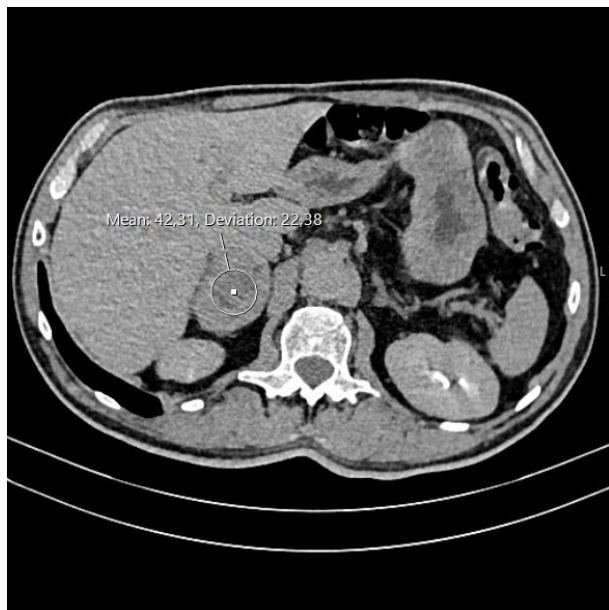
Computed tomography (CT) non-contrast scan of the abdomen. A sharply demarcated heterogeneous mass of the right adrenal gland with a density of 26 HU is observed, which raises the suspicion of pheochromocytoma.*
